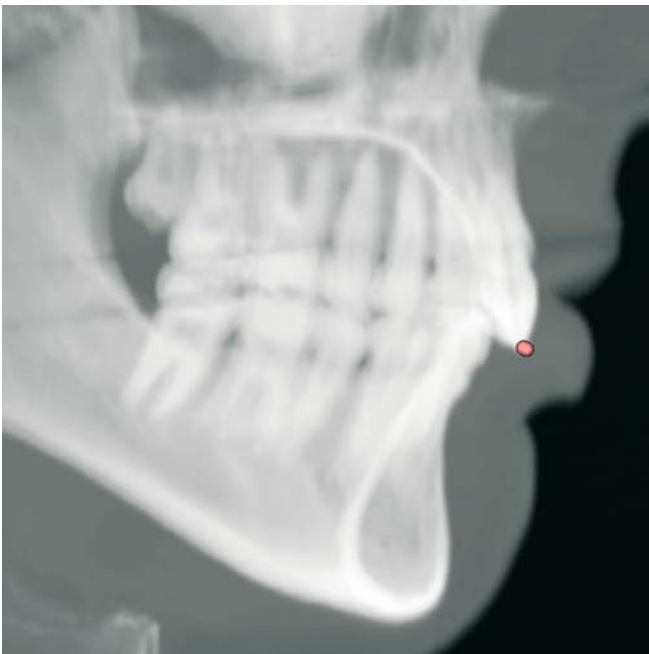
Upper Incisor (UI_r – UI_l) landmarks. Virtual lateral cephalogram (3-D CT, patient K.C.)
